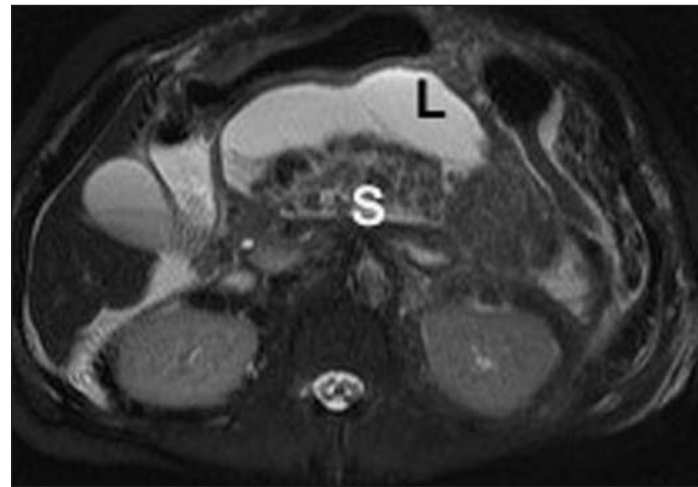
MRI of pancreatic fluid collection that appeared homogenous by CT scan. The patient had suffered severe necrotizing pancreatitis 6 weeks previously. The liquid component (L) has a whitish appearance while the solid component (S) appears black.
